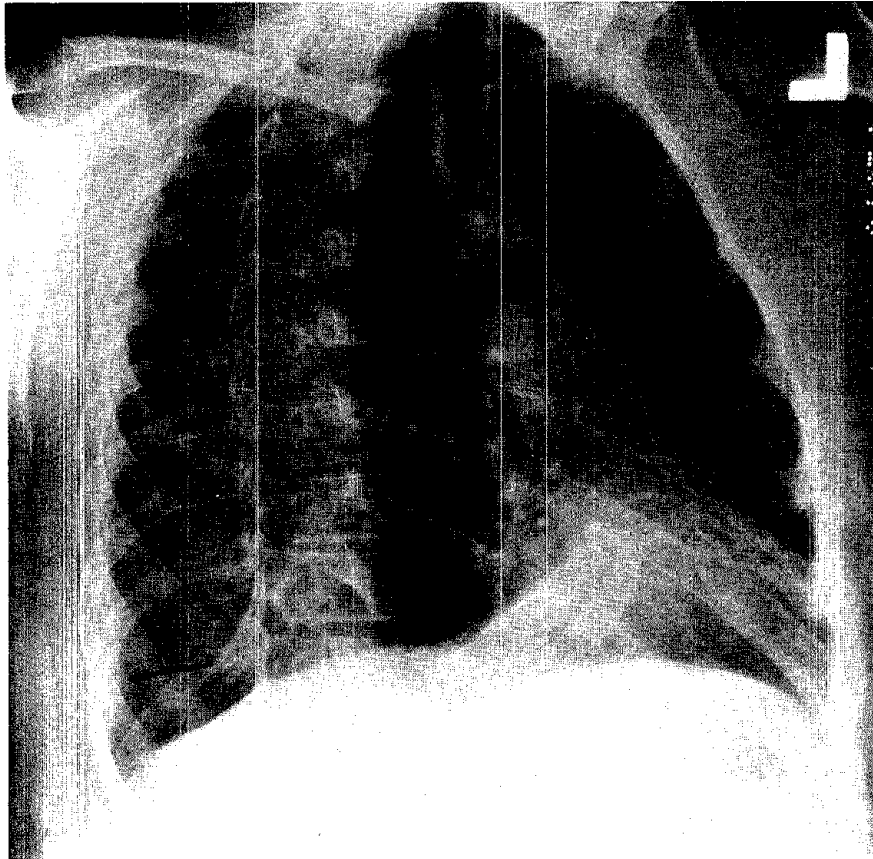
Right anterior oblique chest radiograph, correctly positioned. Arrow points to pleural plaque seen in profile.
